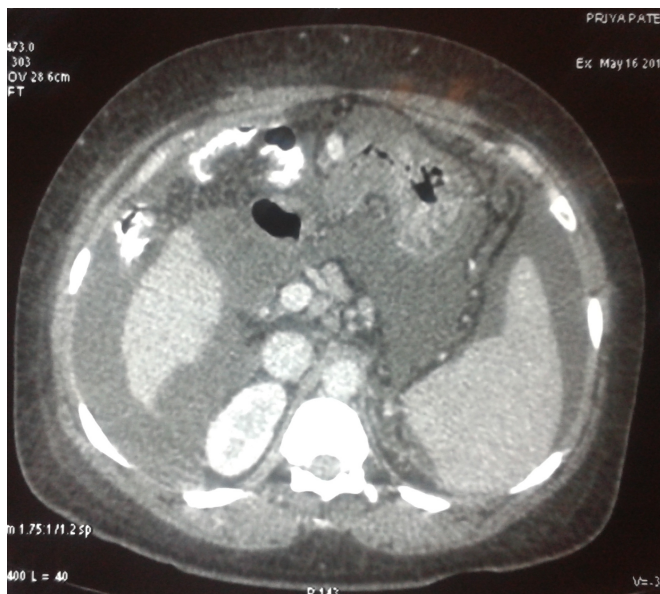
CT showing a shrunken nodular liver ascites splenomegaly and patent portal vein
